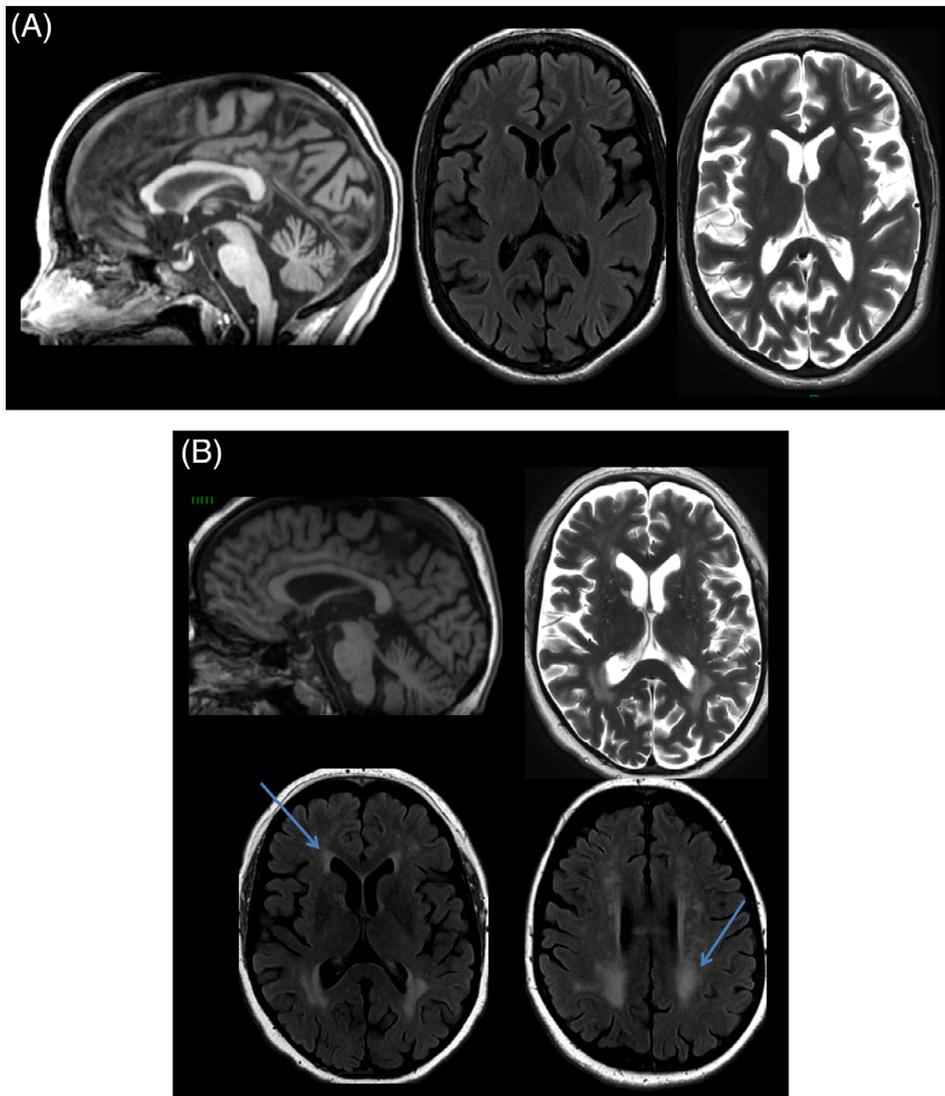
Brain magnetic resonance imaging in cystinosis patients. A, Cortical atrophy. B, major white matter hypersignals
